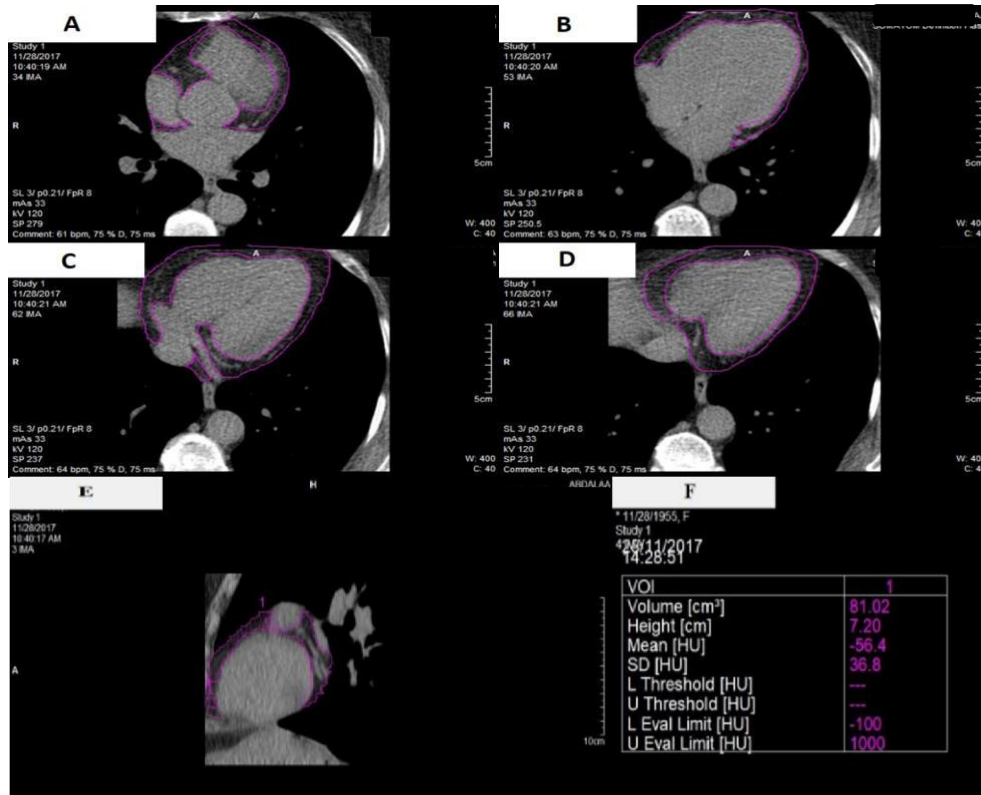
Measurement of epicardial fat volume (EFV) by computed tomography. The area of interest was defined by the manual delineation of the epicardial fat and the volume was calculated in a semi-automatic way by specific software as shown in slide (F) 81.02 cm³.
